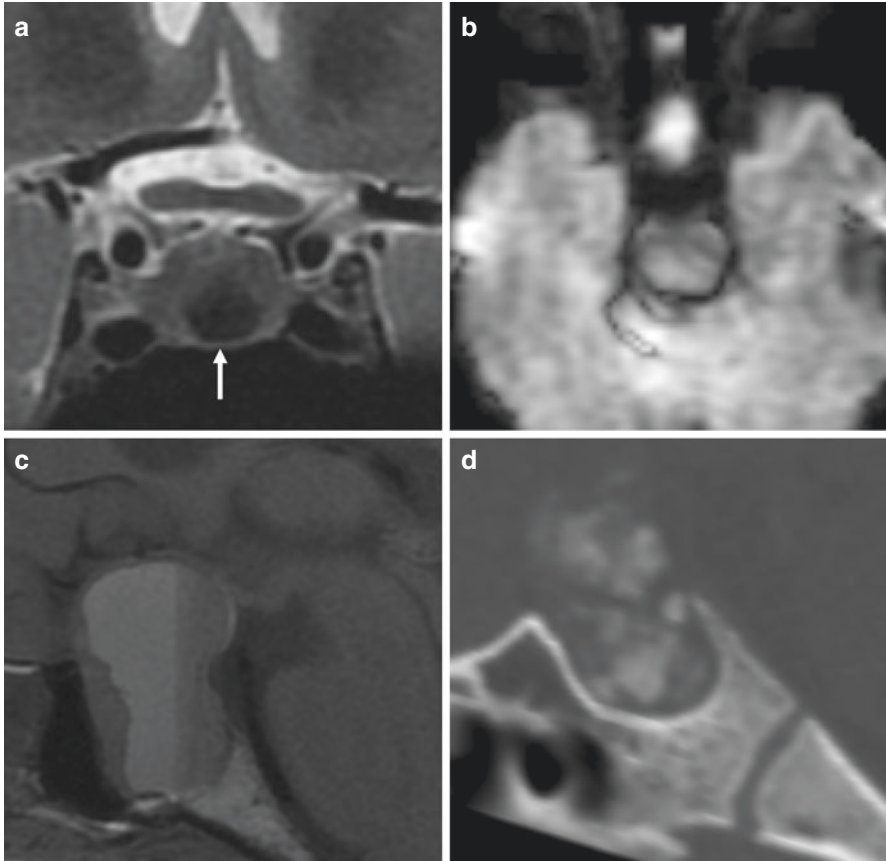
Characteristic imaging findings of four different sellar lesions. (a) T2-weighted coronal imaging shows a T2 hypointense nodule (arrow), characteristic of a Rathke cleft cyst. (b) Axial diffuse weighted imaging shows restricted diffusion in a sellar mass, characteristic of a pituitary abscess. (c) Non-contrast T1-weighted sagittal image shows a blood fluid level in a large pituitary mass, seen in the setting of pituitary apoplexy. (d) Non-contrast sagittal CT shows a large calcified sellar mass, characteristic of an adamantinomatous craniopharyngioma. Note the non-fused sphenoid-occipital synchondrosis that does not fuse until adolescence
